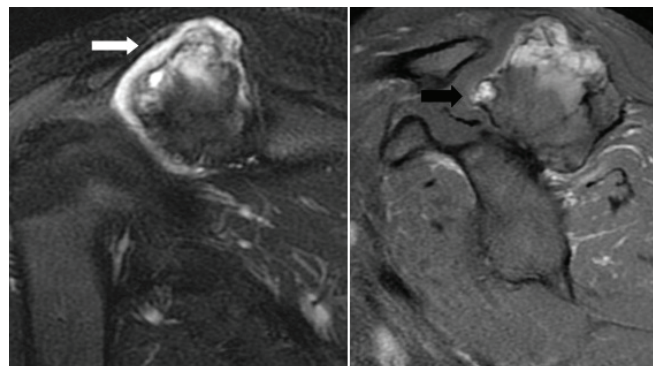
Coronal and sagittal fat-suppressed MRI image showing a thin layer of the cartilage outlines the osseous projection (white arrow) and osteochondroma arising from posterior glenoid (black arrow).
